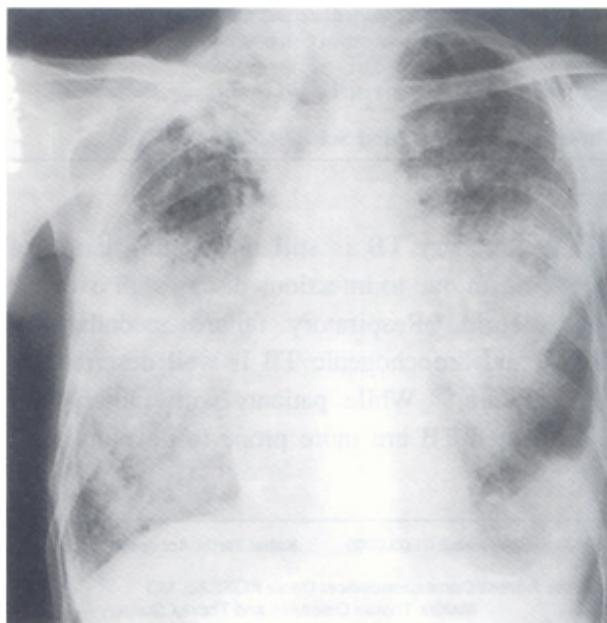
Posterior-anterior chest radiography of the patient showing bilateral reticulo-nodular infiltrates predominantly at the middle zones.
